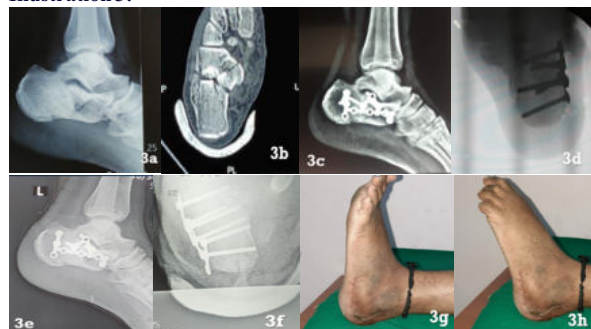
3a- preoperative radiograph showing left calcaneum fracture; 3b- preoperative CT scan showing sander's type 4 fracture; 3c- immediate post operative radiograph lateral view; 3d- immediate post operative radiograph axial view; 3e- 9 months follow up radiograph lateral view; 3f- 9 months follow up radiograph axial view; 3g and 3h- clinical images on 1 year follow up.
